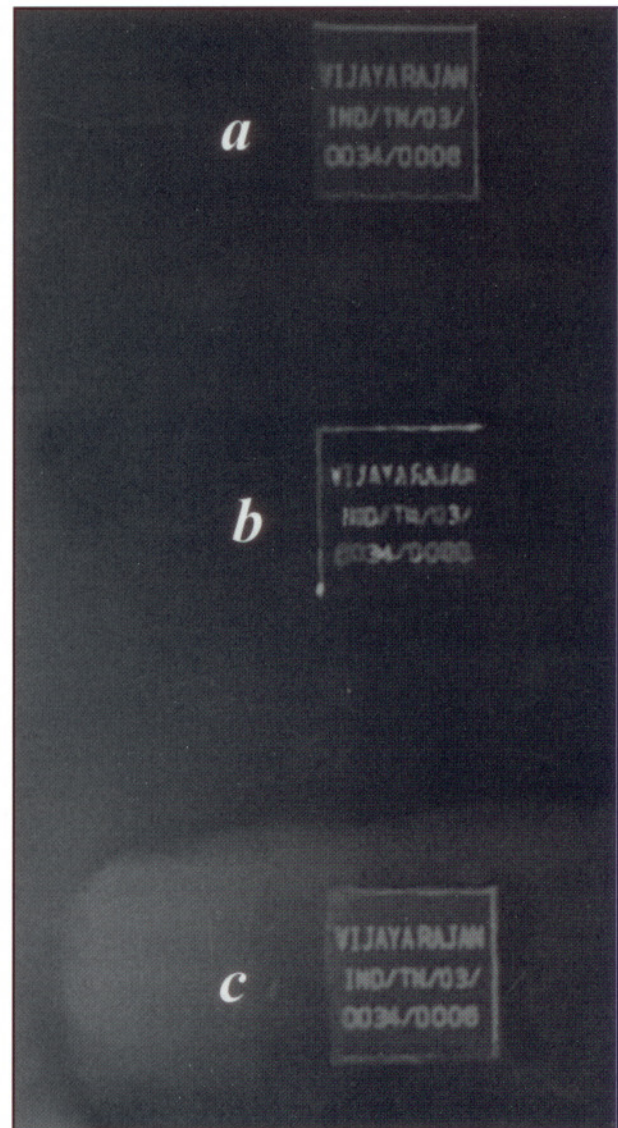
Microchips radiographed on dental film and by conventional dental X-ray machine (a) Microchip under normal conditions, (b) Microchip after heating at 600°C, (c) Microchip after immersion in sulphuric acid at eight weeks
